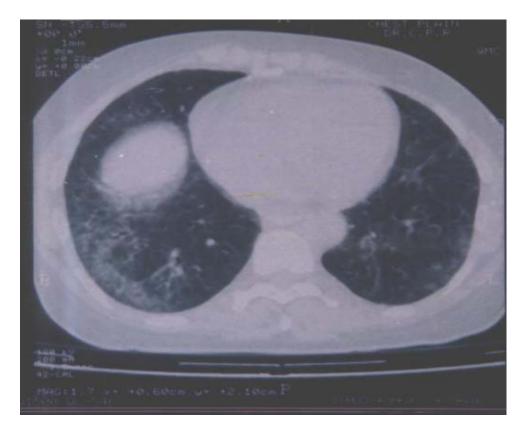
HRCT showing inter ,intra lobular septal thickening and nodular opacities pattern in both lower lobes, more on the right side
